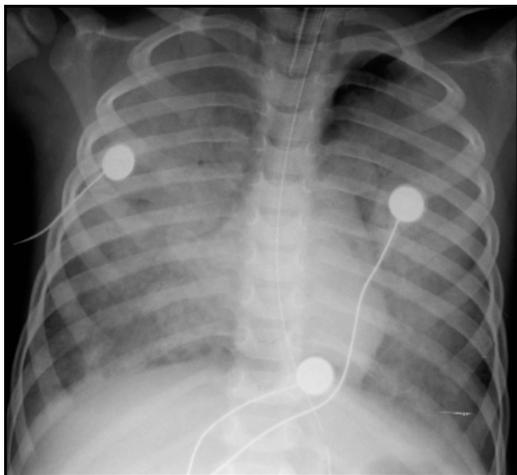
Initial Chest X-Ray in PICU showing diffuse bilateral infiltrates
